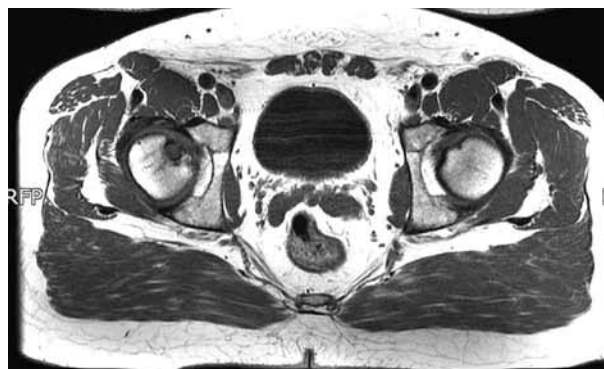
Post-operative MRI at 6 months, axial view. The Trufit ® Plug is visible *in situ*.
